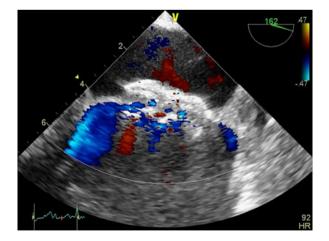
A transesophageal echocardiogram demonstrating a deployed occluding device in one of the atrial septal defects. Residual shunt is present within the perimeter of the device (*arrow*)
